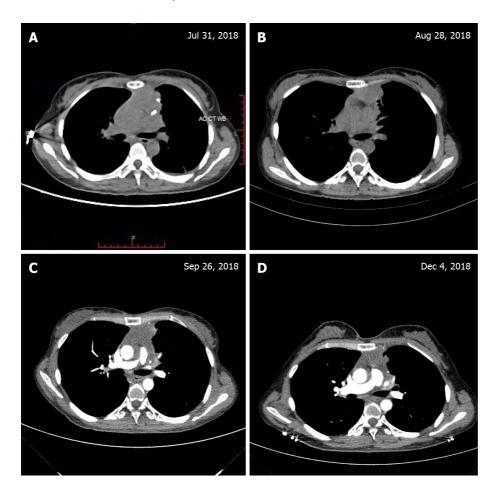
Serial high-resolution computed tomography scans of the chest. A: The computed tomography (CT) scan on July 31, 2018 showing an anterior mediastinal mass with calcification; B: The CT scan on August 28, 2018 showing that the anterior mediastinal mass was improved during the treatment; C: The CT scan on September 26, 2018 showing that the anterior mediastinal mass decreased during the treatment; D: The CT scan on December 4, 2018 showing that the anterior mediastinal mass was stable after treatment.
